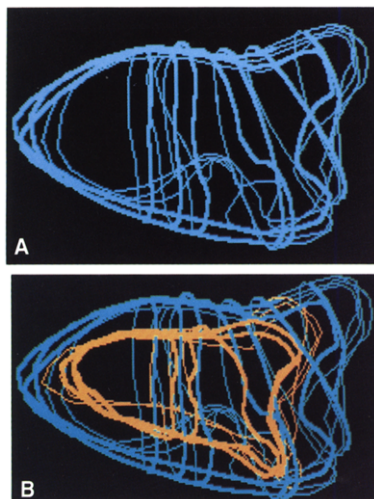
Left ventricle reconstructed from para-apical long-axis and parasternal short-axis views in vivo at end-diastole (A) and with peak systole superimposed (B).
